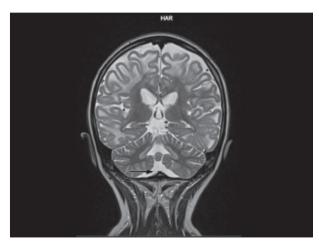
MRI – coronal T2 weighted image: confluent subcortical white matter lesions predominantly of frontal-parietal lobes and atrophy of the cerebellar vermis (black arrow)
